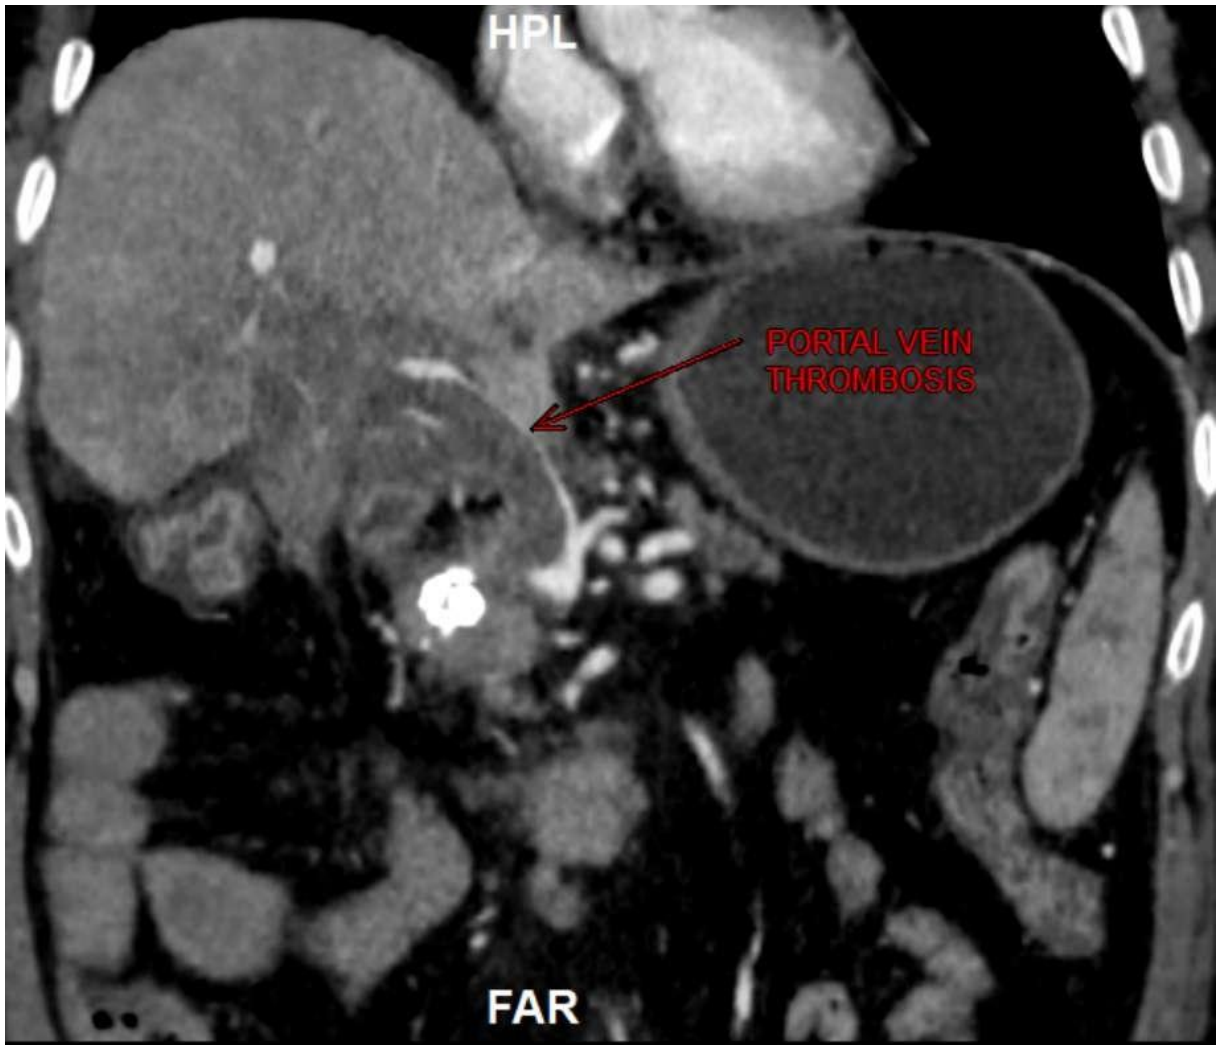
A CASE OF COVID-19 PATIENT WHO UNDERWENT CECT/CT ABDOMINAL ANGIOGRAM AND FILLING DEFECT IN PORTAL VEIN - S/O PORTAL VEIN THROMBOSIS
